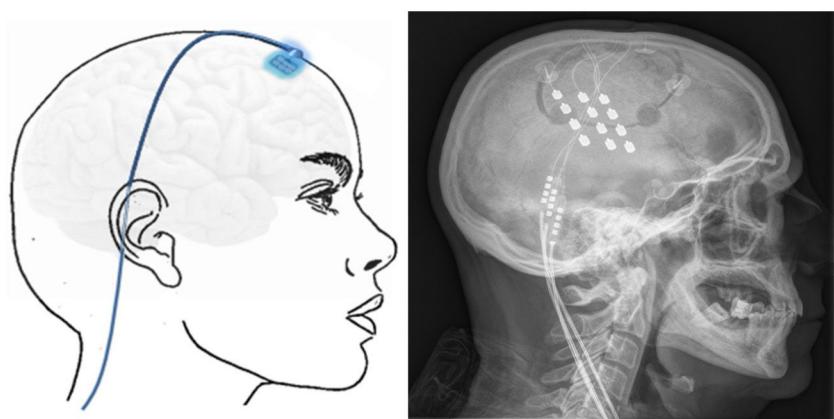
Left: electrodes implanted in the cortical motor area through a frontal burr hole with a subcutaneous lead. Right: head radiography image showing the electrodes implanted in the motor cortex of a patient with contralateral refractory trigeminal neuralgia secondary to multiple sclerosis.
